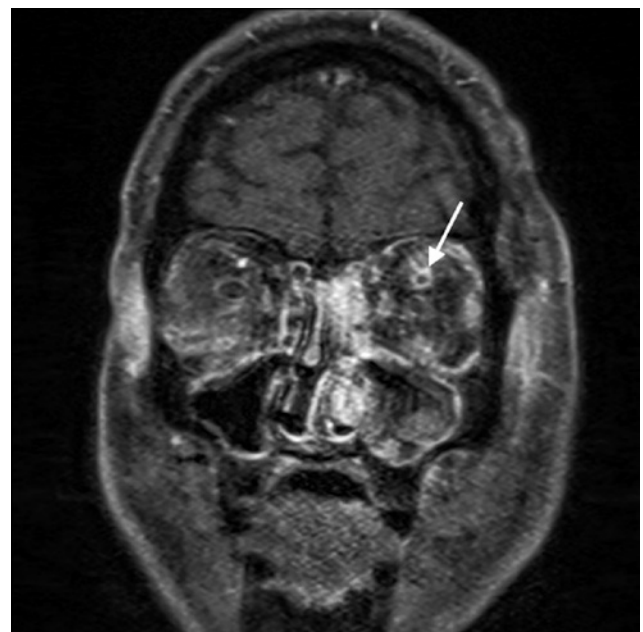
Coronal T1-weighted magnetic resonance image of the orbits and head on day 5, demonstrating a dilated left superior ophthalmic vein with an intraluminal non-enhancing thrombus (arrow), which is indicative of left superior ophthalmic vein thrombosis.
